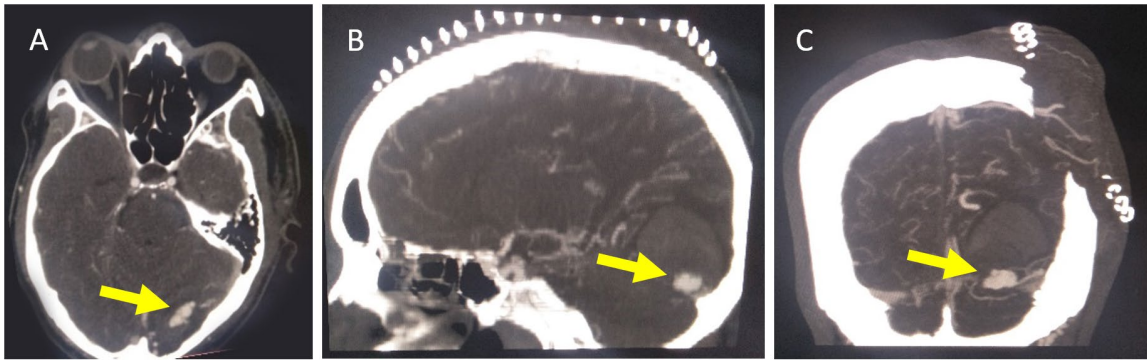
CTA post decompressive hemicraniectomy showing well-defined lobulated dAVF (yellow arrow) in the left occipital lobe. (A) Axial section (B) Sagittal section (C) Coronal section.
